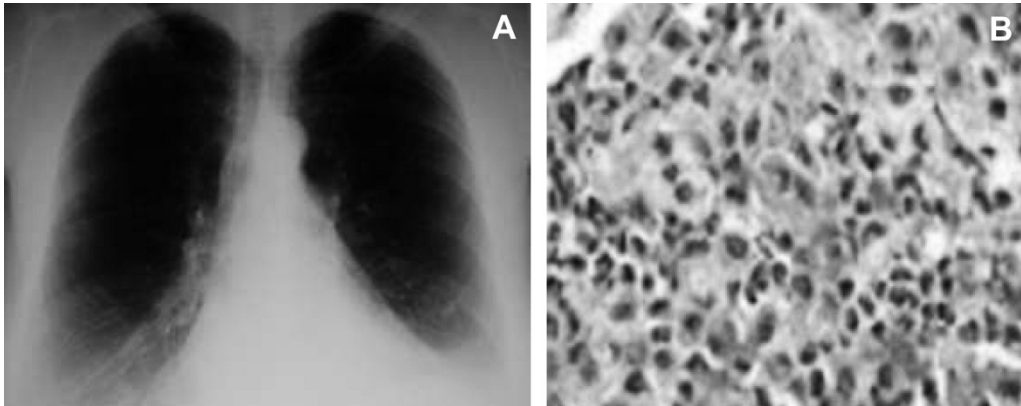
A - X-ray of the chest: transient, patchy, nonsegmental areas of consolidation with predilection for lower zones with the area of consolidation in lower left zone; B- Transbronchial lung biopsy: granulomas, formed by eosinophils with central necrosis, macrophages and giant cells.
